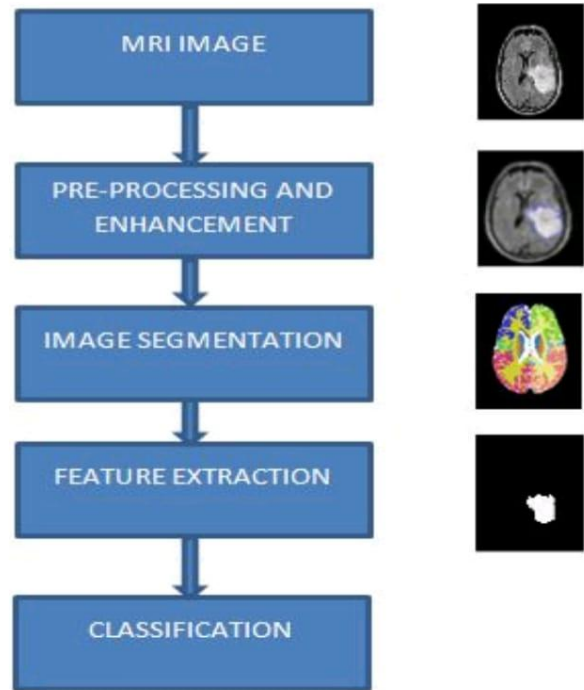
MRI Image Processing
